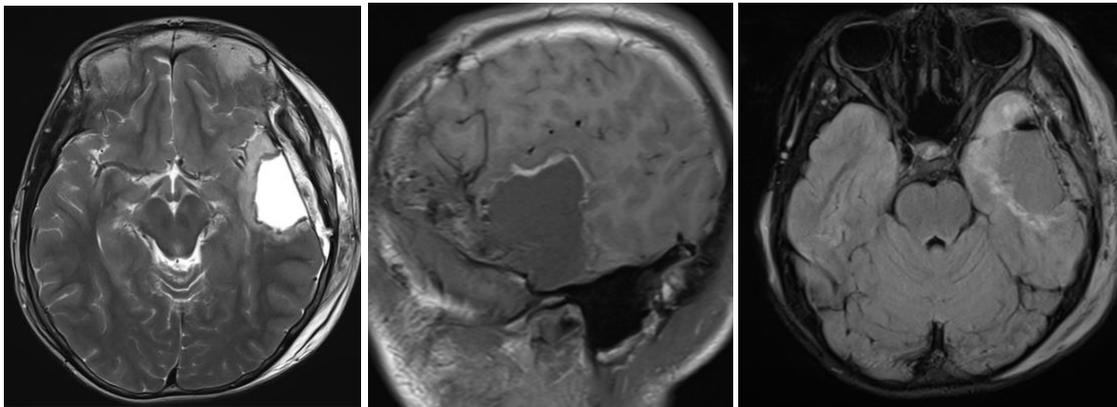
Immediate MRI confirming NTR-resection
